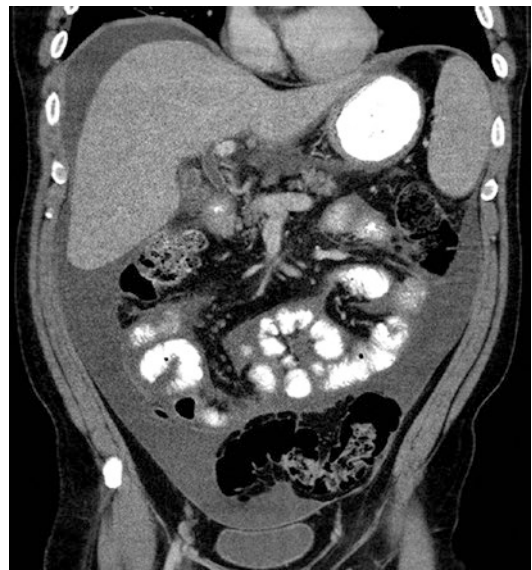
Nonmeasurable lesions according to RECIST. CT scan of abdomen in 45-year-old man with gastric cancer shows large amount of ascites. Cytology of fluid was positive for malignant cells, confirming malignant nature of fluid. (Reprinted with permission from AJR Am J Roentgenol. 2010;195: 281–289)
